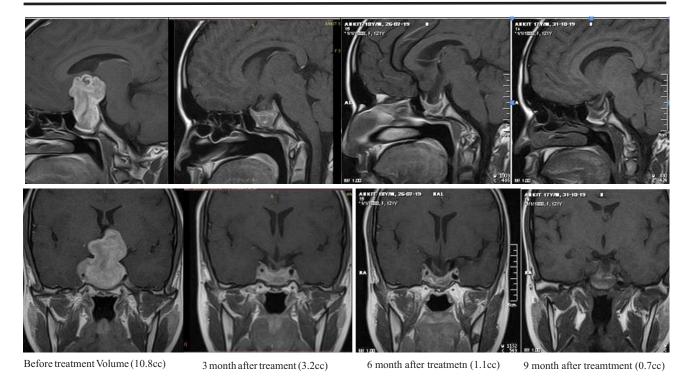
Treatment response of Pituitary macro adenoma by post contrast MRI in sagittal plane (upper row) and coronal plane (lower row).
